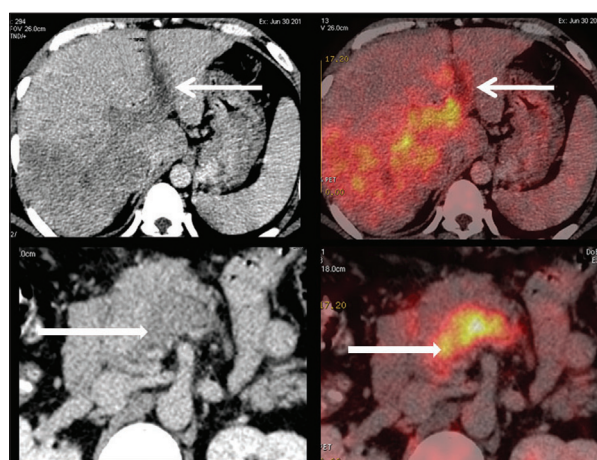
The left panel shows the computed tomography (CT) images and the right panel shows the fused positron emission tomography CT images. The CT images in the left panel shows a filling defect completely occluding the lumen of the right and left portal veins and the main portal vein. The arrow in the right upper panel shows the hypermetabolic tumor thrombus in the branches of the portal vein and in the lower panel the thrombus in the main portal vein
